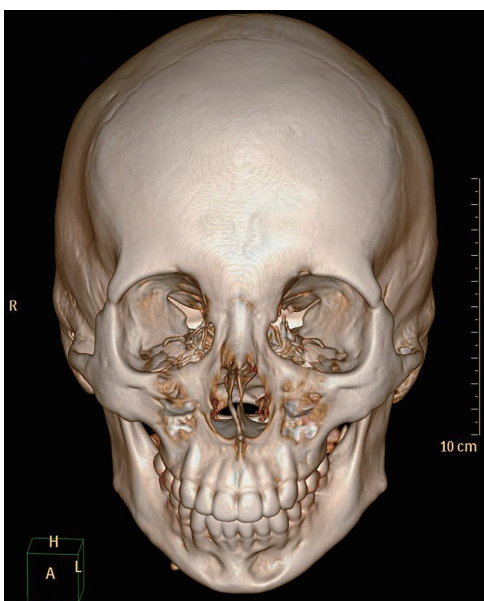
Classic case. Three-dimensional reconstruction of the computed tomographic scans of a 30-year-old woman. She underwent hyaluronic acid injection three times, with more than 1 ml each time. Evident concavities could be found in bilateral incisive fossa.
